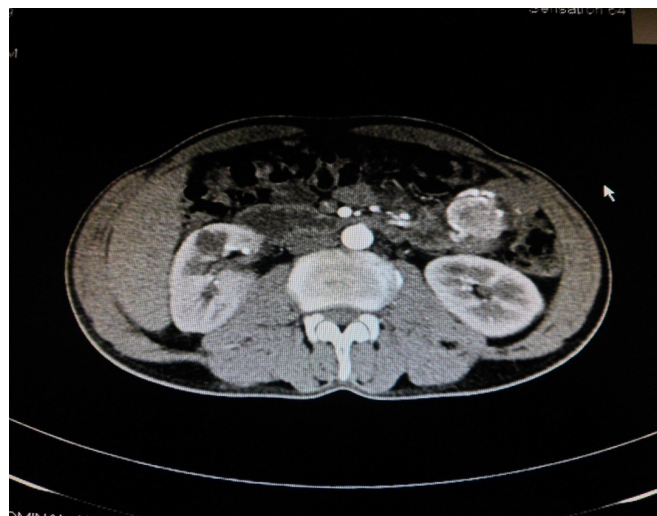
Axial contrast-enhanced CT (CECT) scan showing a well-enhancing lesion 3 cm × 2 cm in size, arising from the proximal jejunum
